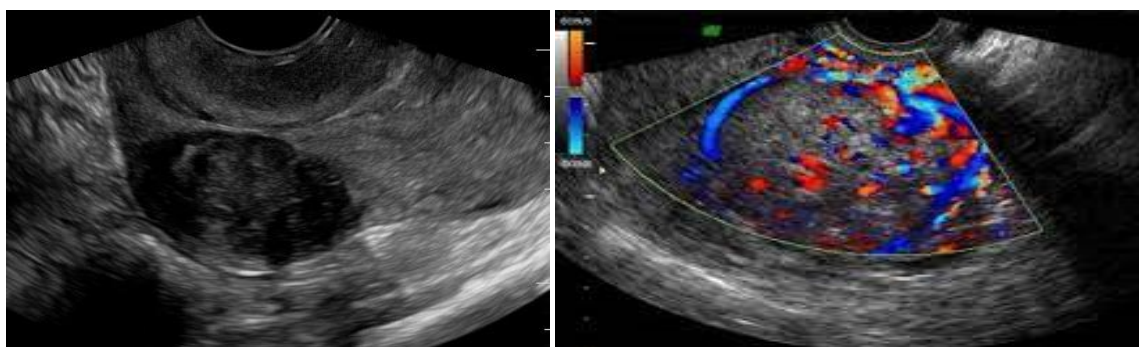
A well-defined hypoechoic mass lesion in intra-mural location noted involving posterior myometrium on trans-vaginal ultrasound.
